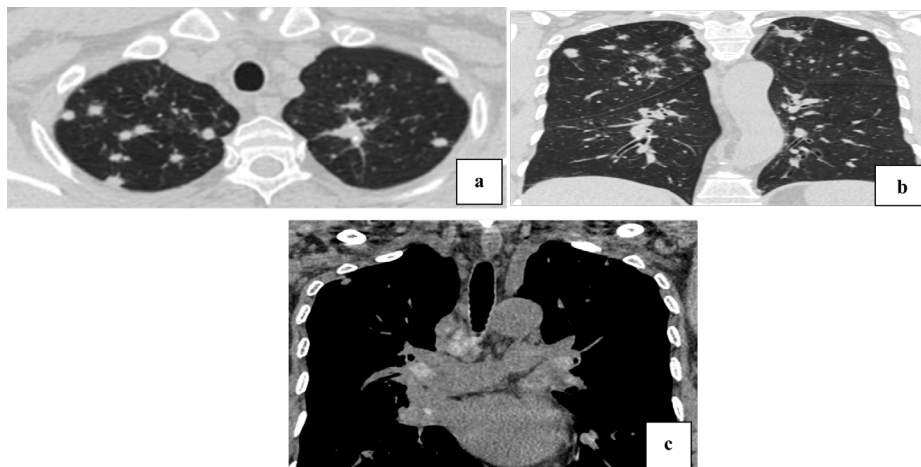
Pulmonary Sarcoidosis in a 35-year-old Male Patient. (a & b) CT Chest, Axial and Coronal Reformats in the Pulmonary Window Reveal Multiple Bilateral ill-defined Small Nodules Predominantly Situated in the Upper Lobes, Exhibiting Lymphatic Distribution: Peri-bronchovascular, Subpleural, And Interlobular Septa. The Mediastinal Window, in Coronal Reformat, Reveals Several Lymphadenopathies Located Retrocaval, Pretracheal, Aortopulmonary, Subcarinal, and Bilaterally Hilar, with Some Exhibiting Calcification.
